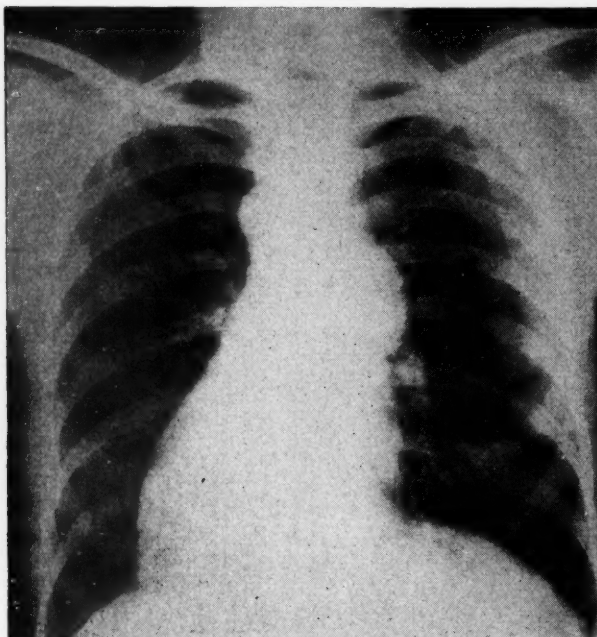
Radiograph of the chest showing dilatation of the first portion of the ascending aorta, not aneurysmal in the sense of a diseased process in the aortic coats.
